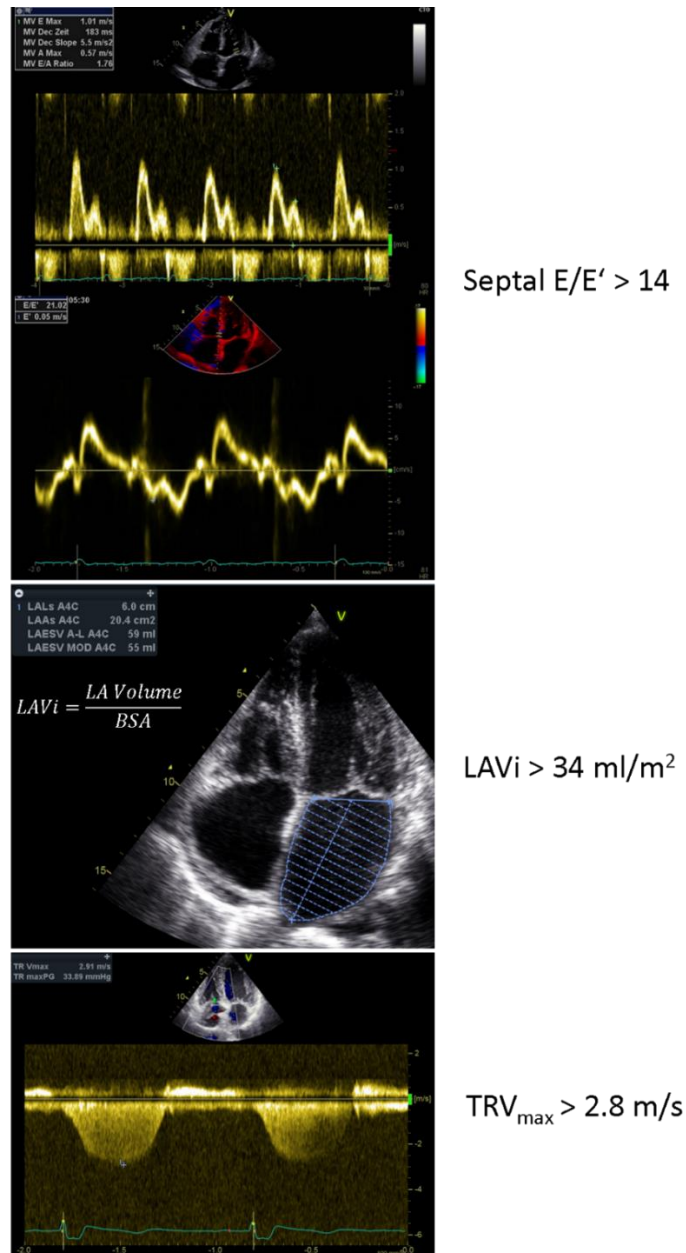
Diastolic function related echocardiographic parameters: septal E/E' ratio, left atrial maximum volume index (LAVi), and peak velocity of tricuspid regurgitation jet (TRVmax). In combination with pulsed-wave Doppler parameters for the evaluation of diastolic filling pattern, diastolic dysfunction was comprehensively identified through these 3 additional parameters abnormalities (septal $E/E' > 14$, $TRV_{max} > 2.8 \text{ m/s}$, and $LAVi > 34 \text{ ml/m}^2$).
